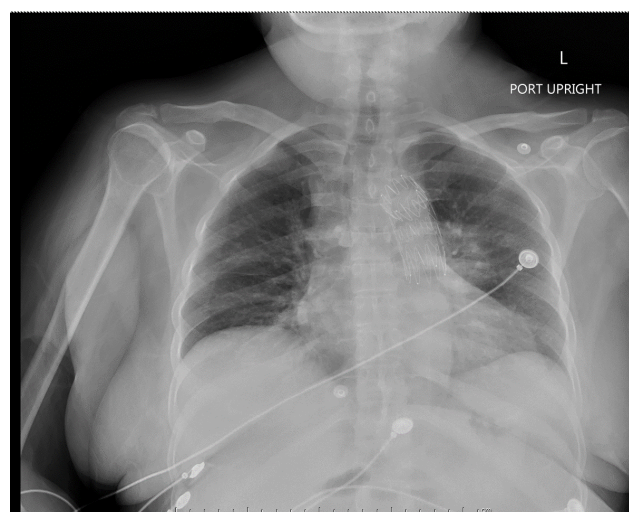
Chest radiograph obtained during admission to outlying hospital with a left hilar opacity. Aortic graft also visible.
